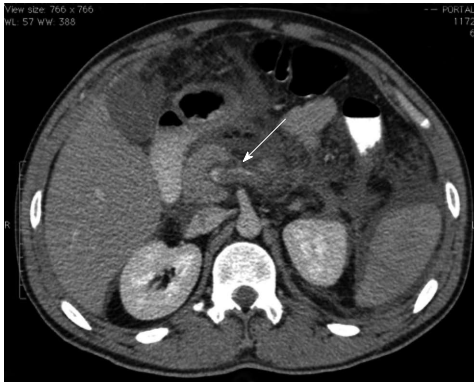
Abdominal computed tomography showing Balthazar C pancreatitis with splenic vein thrombosis (arrow).
